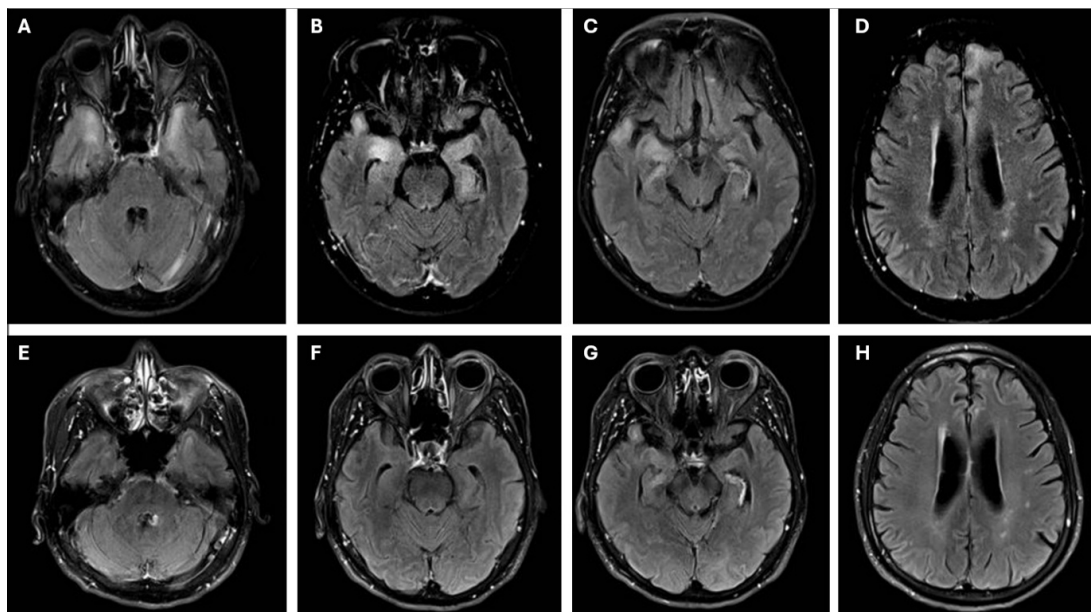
Pre- (A-D) and post-treatment (E-H) contrast enhanced T2-weighted axial MRI slices demonstrating T2 hyperintensities involving the bilateral temporal lobes and limbic structures (A-C), as well as the left parasagittal frontal lobe (D) which improved following a 14-day course of IV benzylpenicillin therapy.
